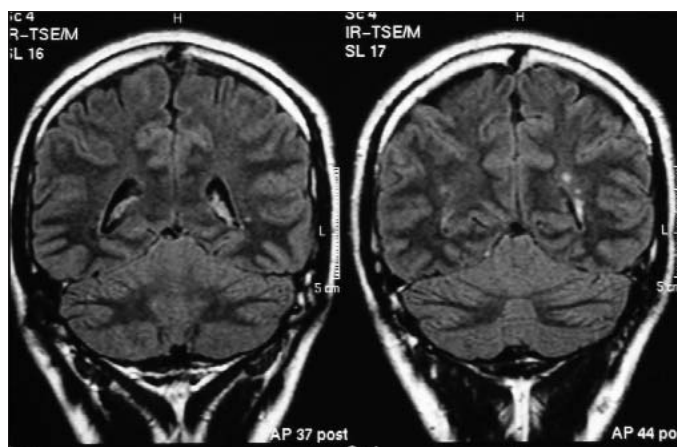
Cranial MRI study of the index case's son. Coronal FLAIR sequences
